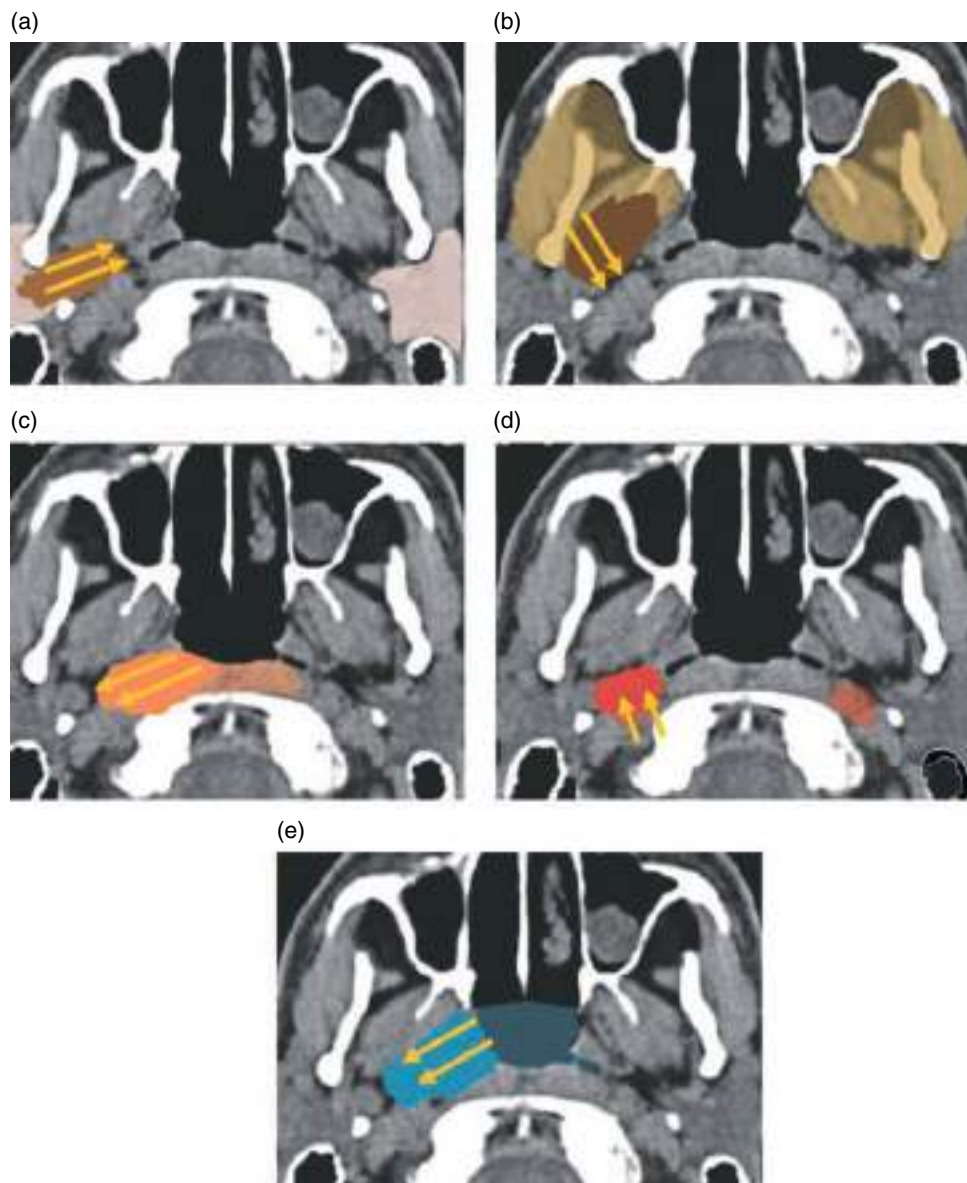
Displacement of the fat in the parapharyngeal space based on the location of lesions in adjacent cervical spaces. (a–e) Axial noncontrast CT images. (a) Lesion in the parotid space: antero-medial displacement. (b) Lesion in the masticator space: posteromedial displacement. (c) Lesion in the perivertebral space: lateral displacement. (d) Lesion in the carotid space: anterior displacement. (e) Lesion in the pharyngeal mucosa: postero-lateral displacement.
